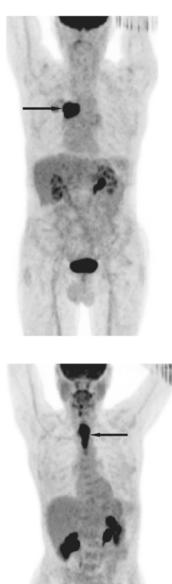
A FDG positive right hilar squamous cell carcinoma.
